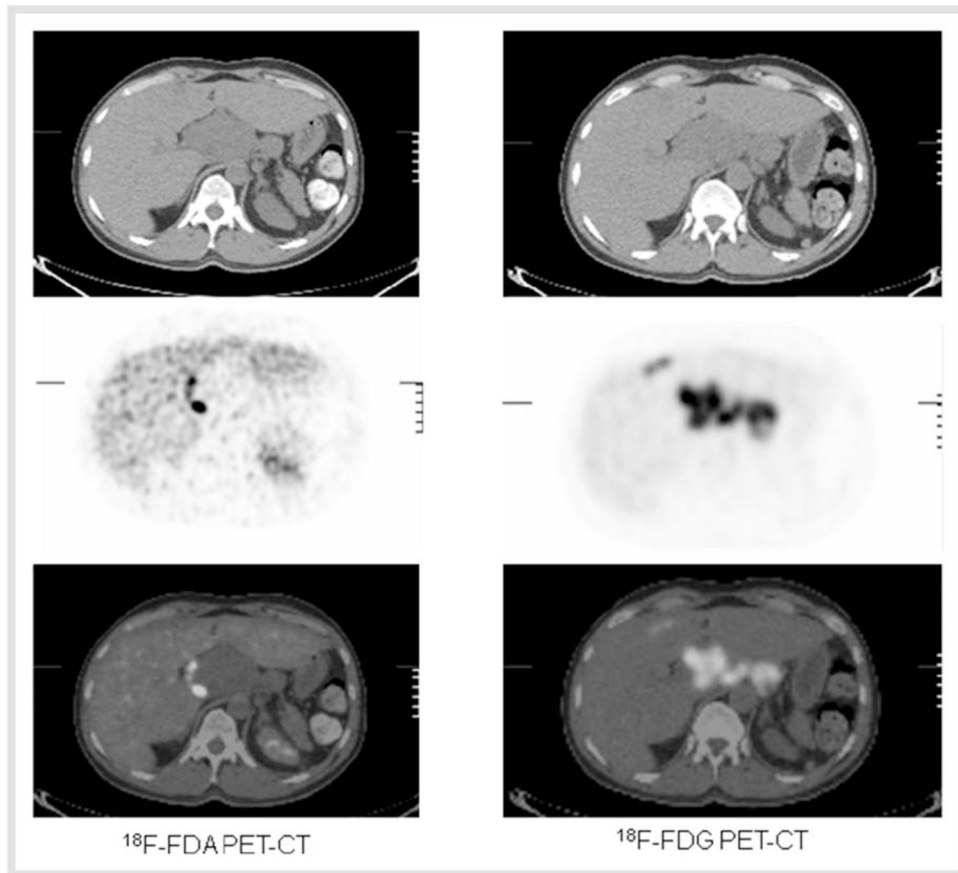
^{18}F -FDA PET-CT (left panels) and ^{18}F -FDG PET-CT (right panels) images in a 35-year-old male with retroperitoneal metastases of an SDHB-related PPGL. CT images (upper panels), axial PET images (middle panels), axial PET-CT fused images (lower panels).
